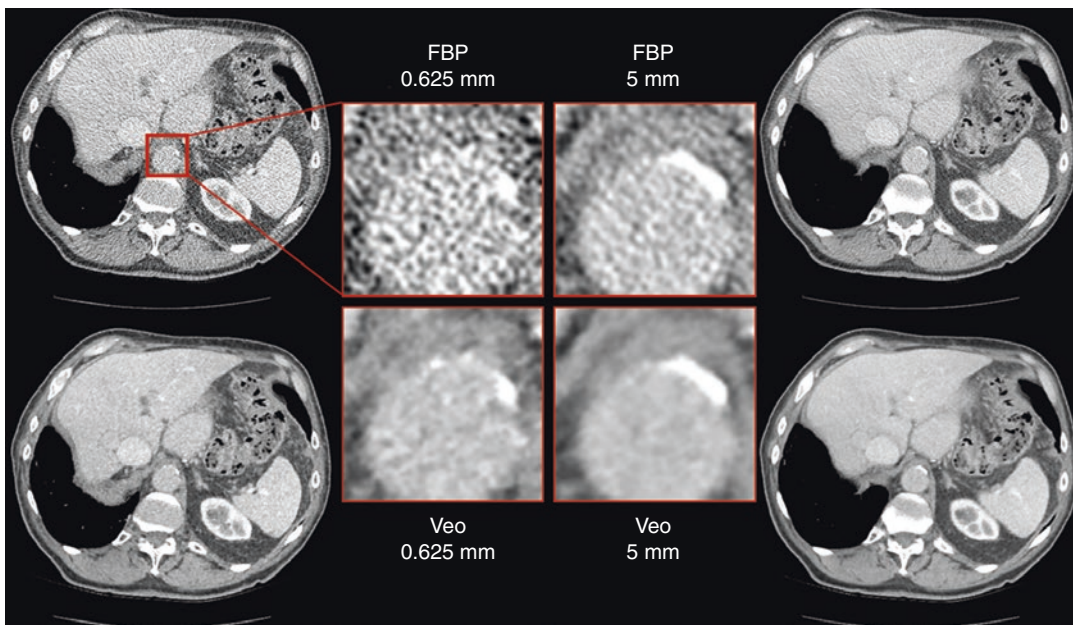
Abdominal CT images of a human subject generated with two reconstruction slice thicknesses (0.625 vs. 5 mm) and two algorithms (FBP vs. Veo). Although all four images showed calcium deposition(s) in the descending aorta, the thin slice (0.625 mm) Veo image provided clearer
